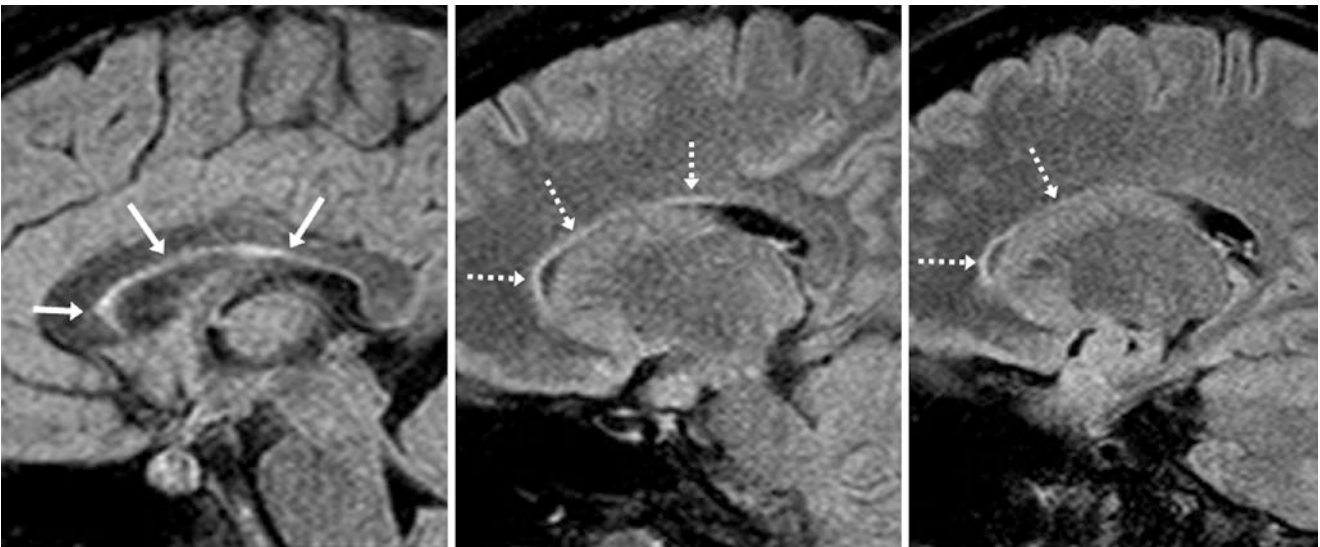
A 24 year old with normal, mild hyperintense signal (arrows) parallel to the lateral ventricles on a midline sagittal FLAIR image (left) at the callosal-septal interface. More laterally, sagittal FLAIR images of the right (middle), and left (right) sides demonstrate
